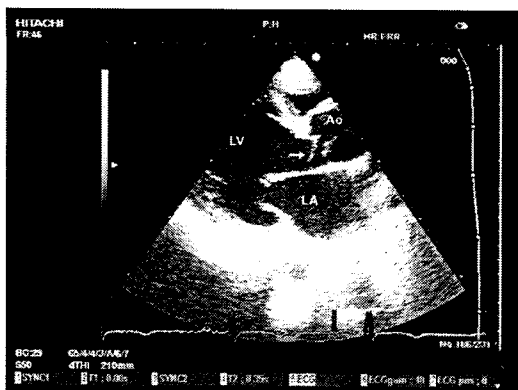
Two dimensional echocardiography in the parasternal long axis view shows the ruptured right aortic valve cusp (arrow). LV, left ventricle; LA, left atrium; Ao, aort
